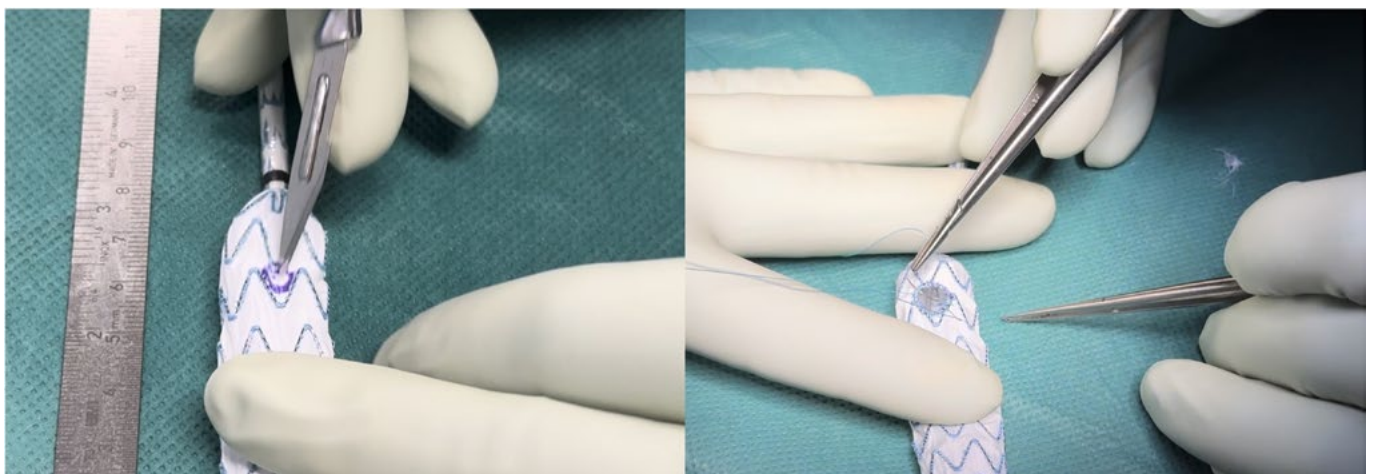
Construction of a physician-modified endograft (PMEG). (A) Creation of a fenestration on the endograft fabric after target vessel marking and sizing. (B) Circumferential reinforcement of the fenestration with a running polypropylene suture to improve radiographic visualization and maintain fenestration integrity during device manipulation and deployment.
